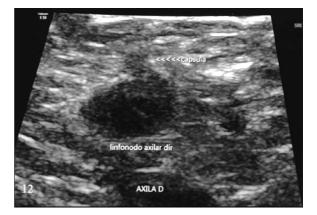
ultrasound of the right axillary region showing a hypoechoic atypical lymph node with a thickened cortex and no fatty hilum.
